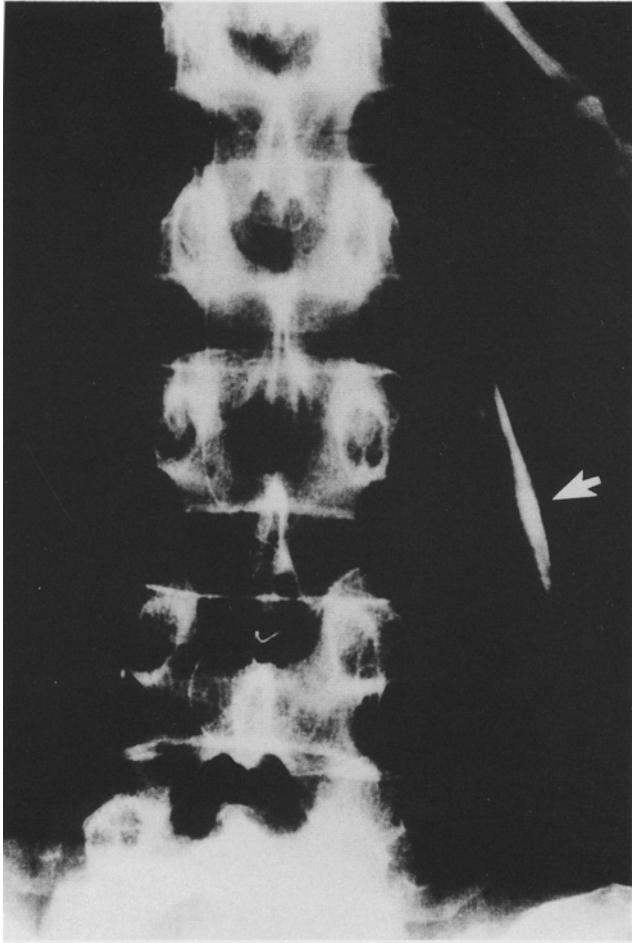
Anteroposterior view roentgenogram. The radiopaque dye, indicated by a *white arrow*, flows lateral from the third to the fifth transverse process of the lumbar vertebrae
